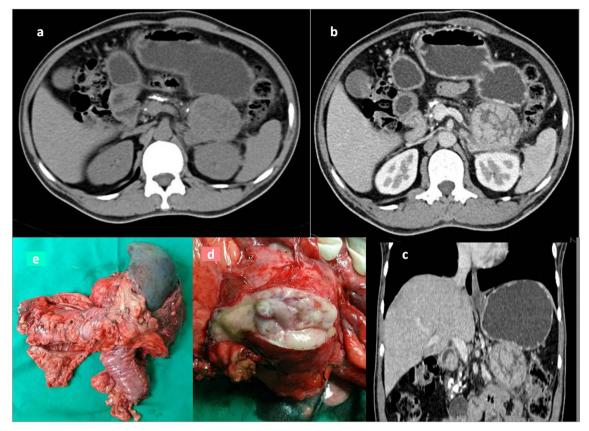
a Noncontrast CT image, white arrow showing multiple radio opaque calculi in main pancreatic duct. b Contrast-enhanced CT image showing a solid enhancing mass in the distal body and tail of pancreas with central and radial areas of non enhancement. Splenic vein thrombosis seen. Planes with the left kidney and the adrenal appeared clear. c
